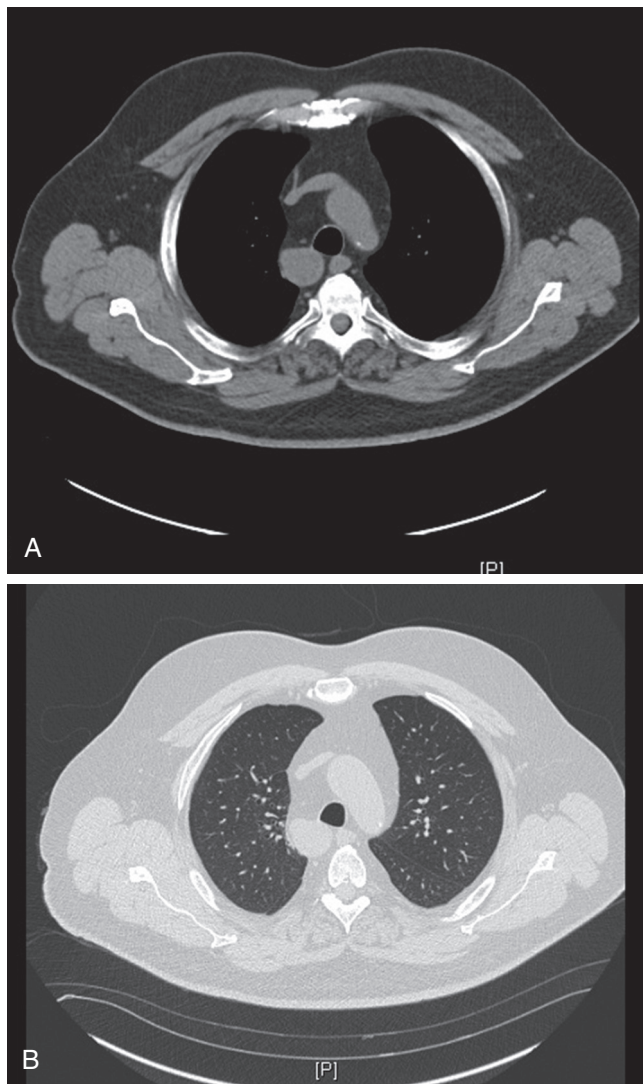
■ CT scan of a schwannoma showing the proximity to the vertebral body and the trachea seen on both the mediastinal window (A) and parenchymal window (B). (Courtesy Dr. John Kucharczuk.)
